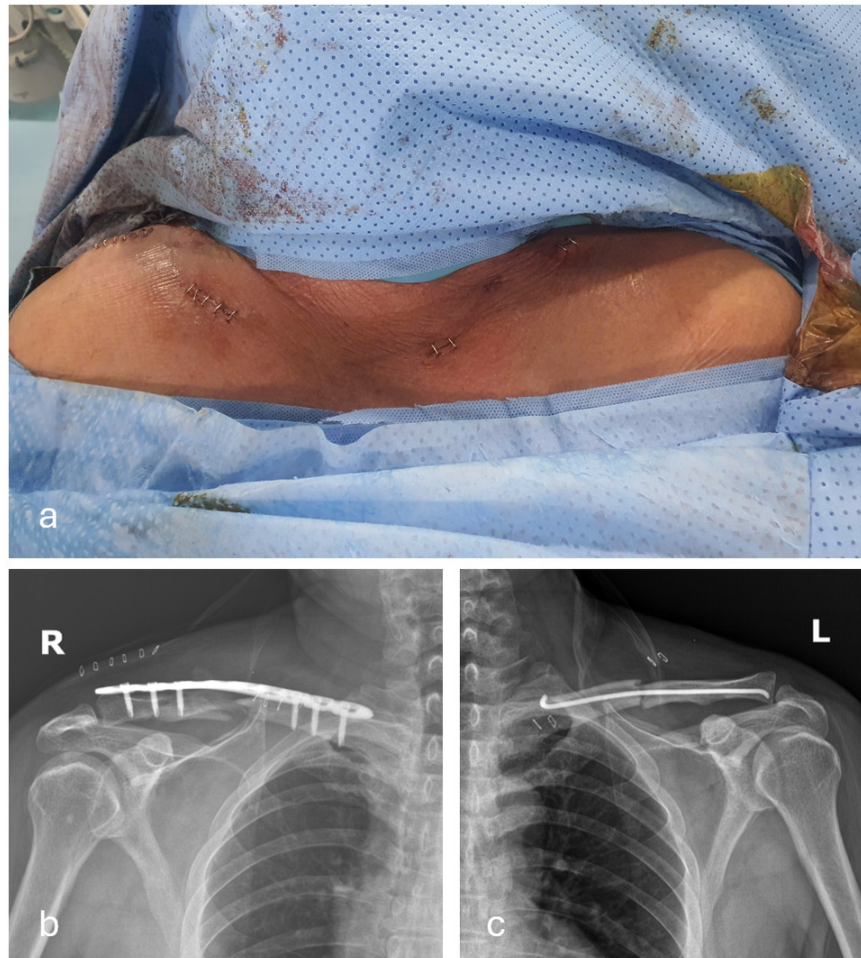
a: Surgical incisions for bilateral clavicle fractures; b: Postoperative X-ray of the right clavicle; c: Postoperative X-ray of the left clavicle.
